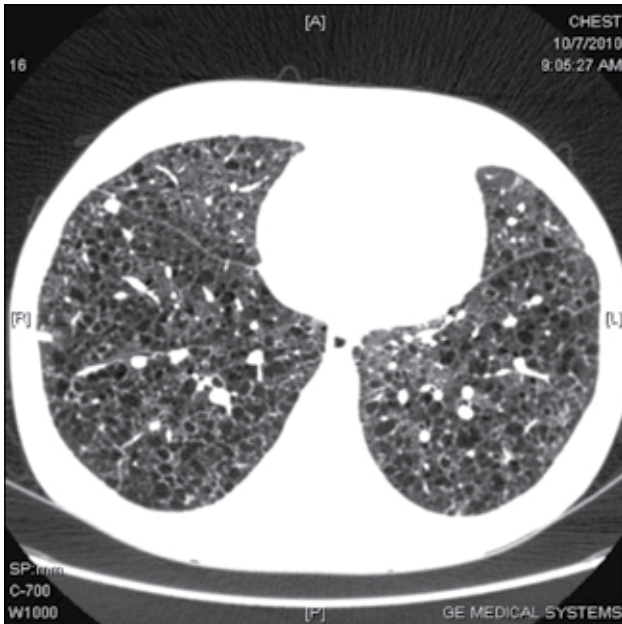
High-resolution computed tomography scan of the chest in a patient with advanced pulmonary Langerhans Cell Histiocytosis shows numerous variably sized pulmonary cysts and nodules that are confluent at some places
